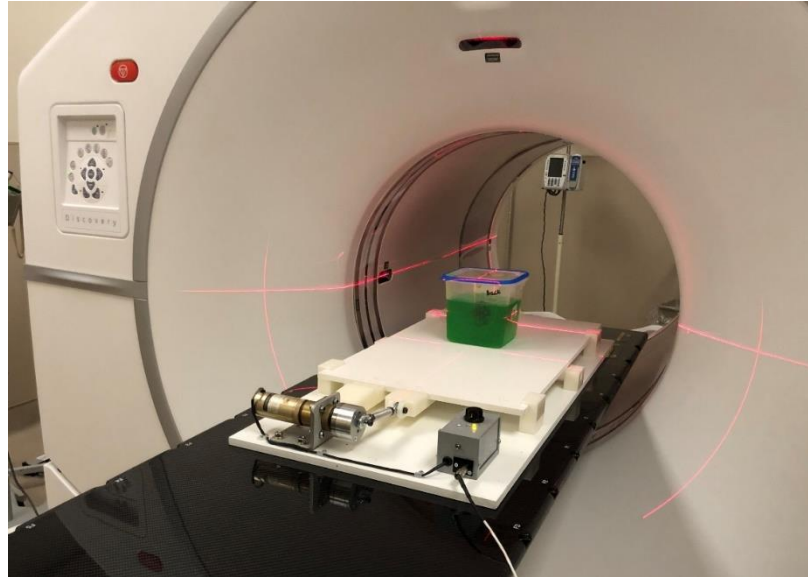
PET/CT setup of irregular lesion scan
